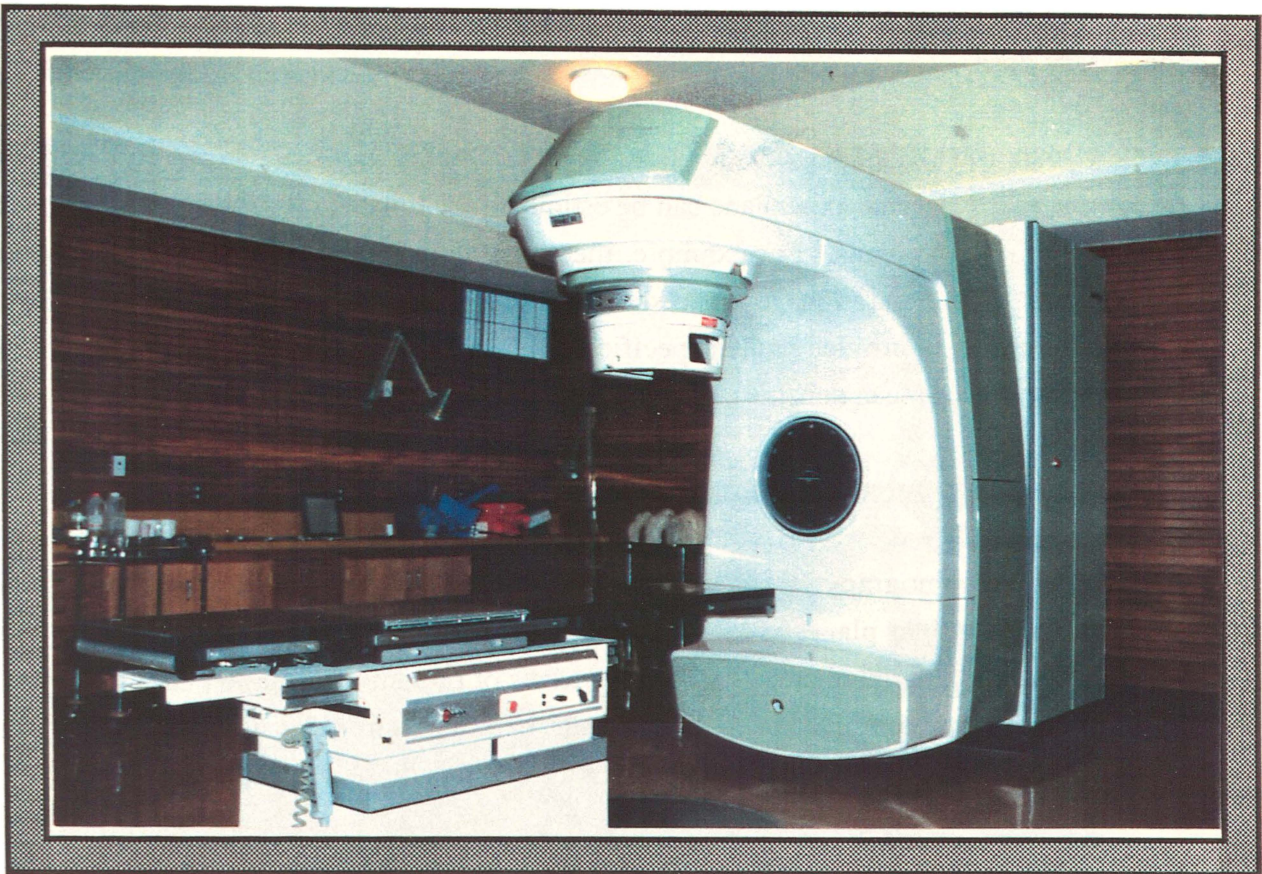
Photograph of a medical linear accelerator. This model is a "Varian Clinac 18". It is situated in a treatment room at the Waikato Hospital radiotherapy centre. This linac is capable of producing 10 MV X-rays and 6, 9, 12, 15, 18 MeV electrons at a dose rate of between 1 and 5 Gy per minute. The machine's centre of rotation (isocentre) is at 100 cm SSD.
